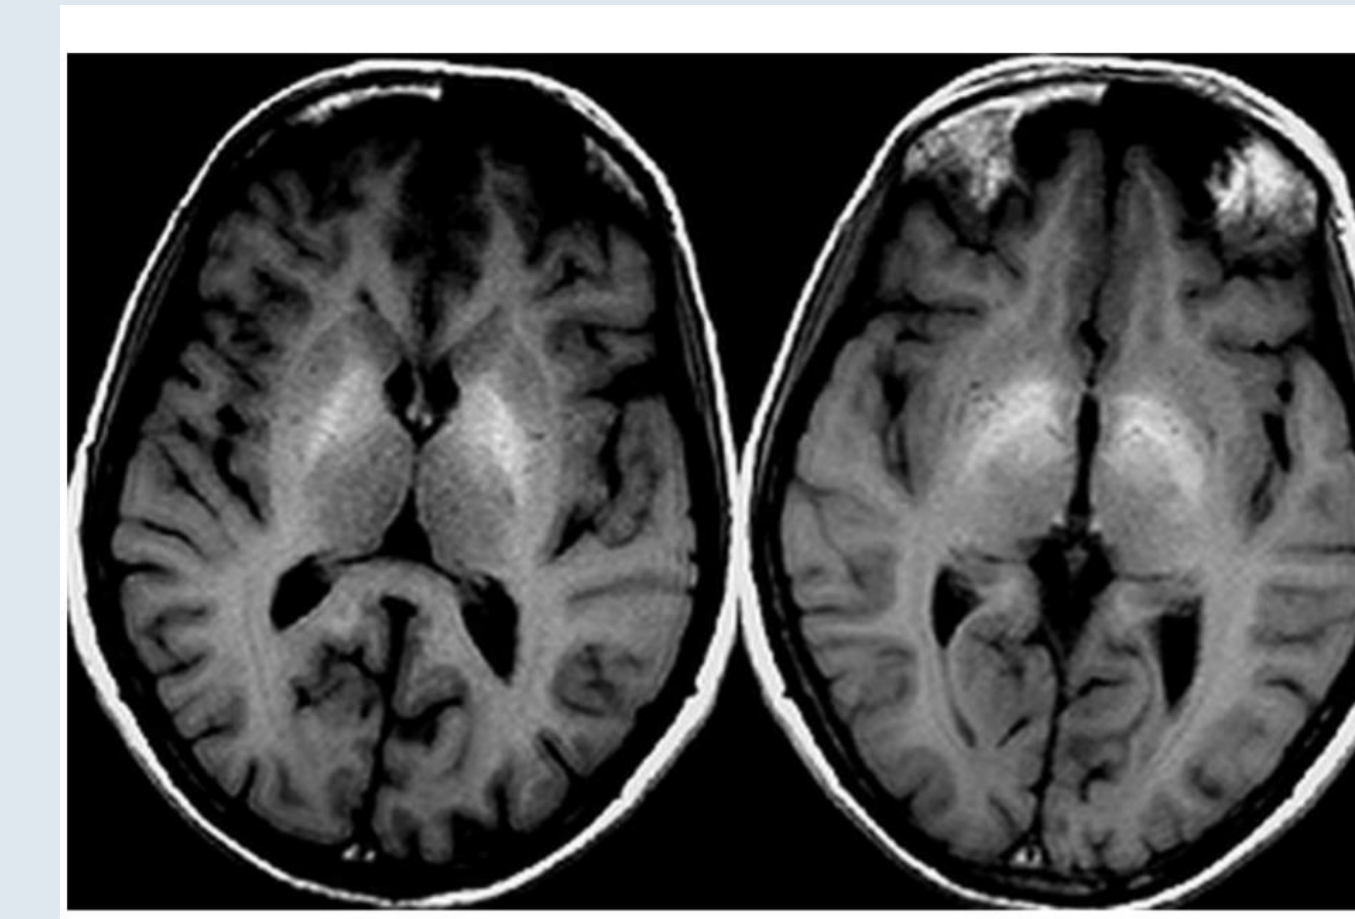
Transverse T1-weighted MR images of the brain in a patient with chronic liver failure and parkinsonism – showing bilateral signal-intensity change involving globus pallidus and the anterior midbrain. (Rovira et al, 2008)
